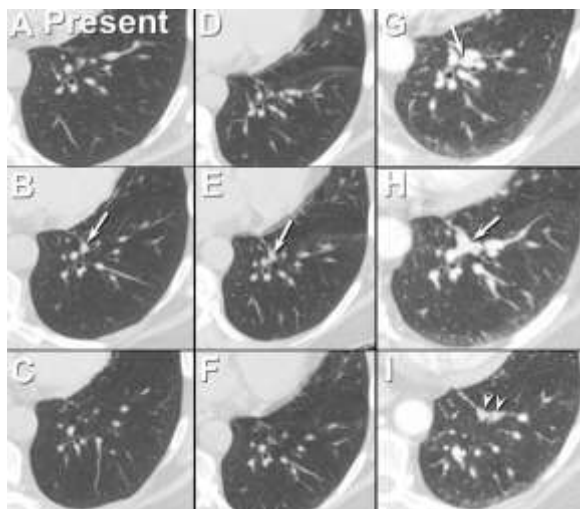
Axial focused unenhanced CT images performed at presentation (Present) show a small nodule in the medial left basal initially overlooked. Images immediately cranial (A) and caudal (C) to the lesion (arrow, B) do not show an abnormality; the nodule (arrow) is visible on one image only. D-F: Axial focused unenhanced images less than one year following presentation again show the lesion visible on one image only (arrow, E) the nodule merges indistinctly with adjacent vessels. G-I: Axial focused enhanced CT 6 years following presentation and bilateral adrenalectomy, and following recurrence of symptoms suggesting Cushing syndrome, shows an enlarging medial left lower lobe nodule (arrows) at the site of the previously overlooked lesion on the two previous CTs. The nodule has a branching configuration (arrow in H), with tubular opacities distal to the lesion (arrowheads in I), suggesting an airway association. Click [here](#) to view Figure 8 in an enlarged separate window.
